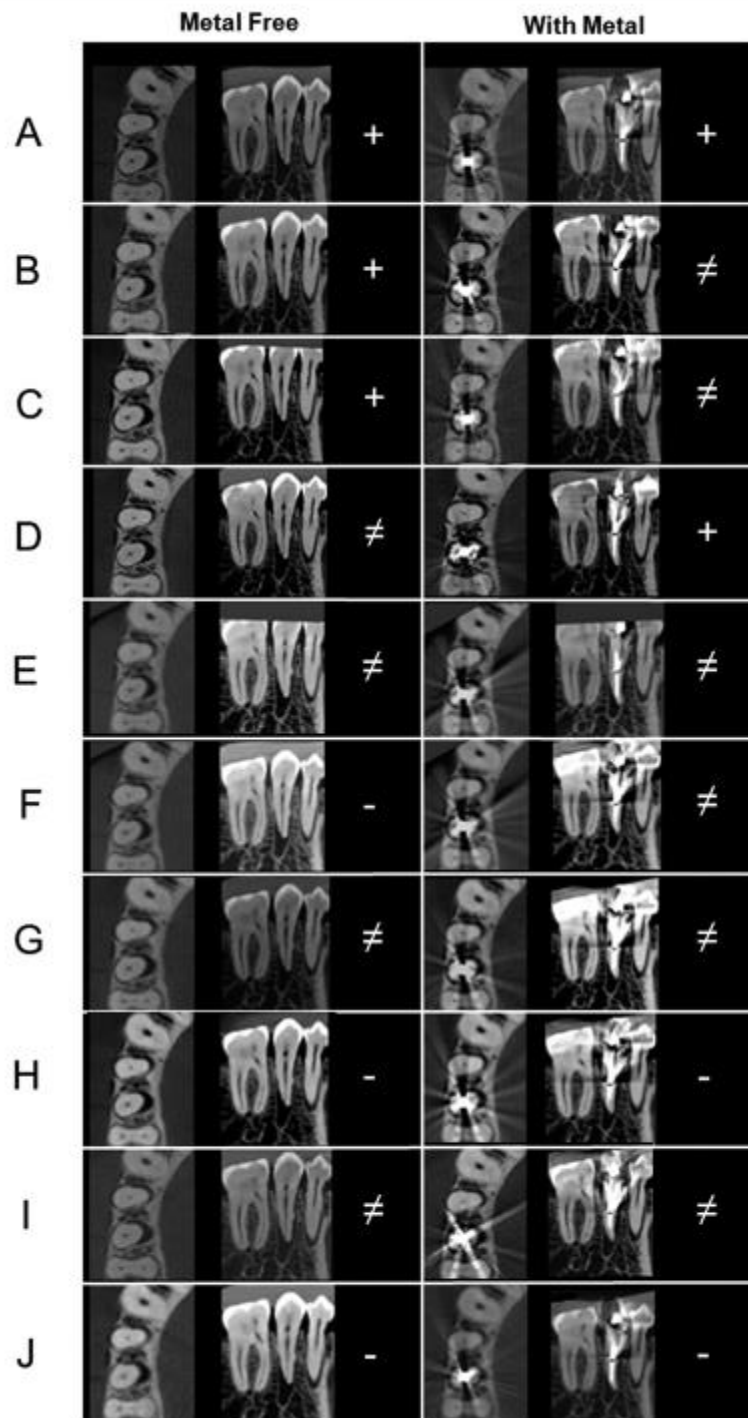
Comparison of CBCT images with the hypothetical best and worst device in two conditions (metal-free and with metal). The CBCT devices marked with + did not differ from the best (95% confidence interval) for all diagnostic tasks, the ones marked with - did not differ from the worst (lower score) and the ones marked with ≠ differed from the best and the worst.
